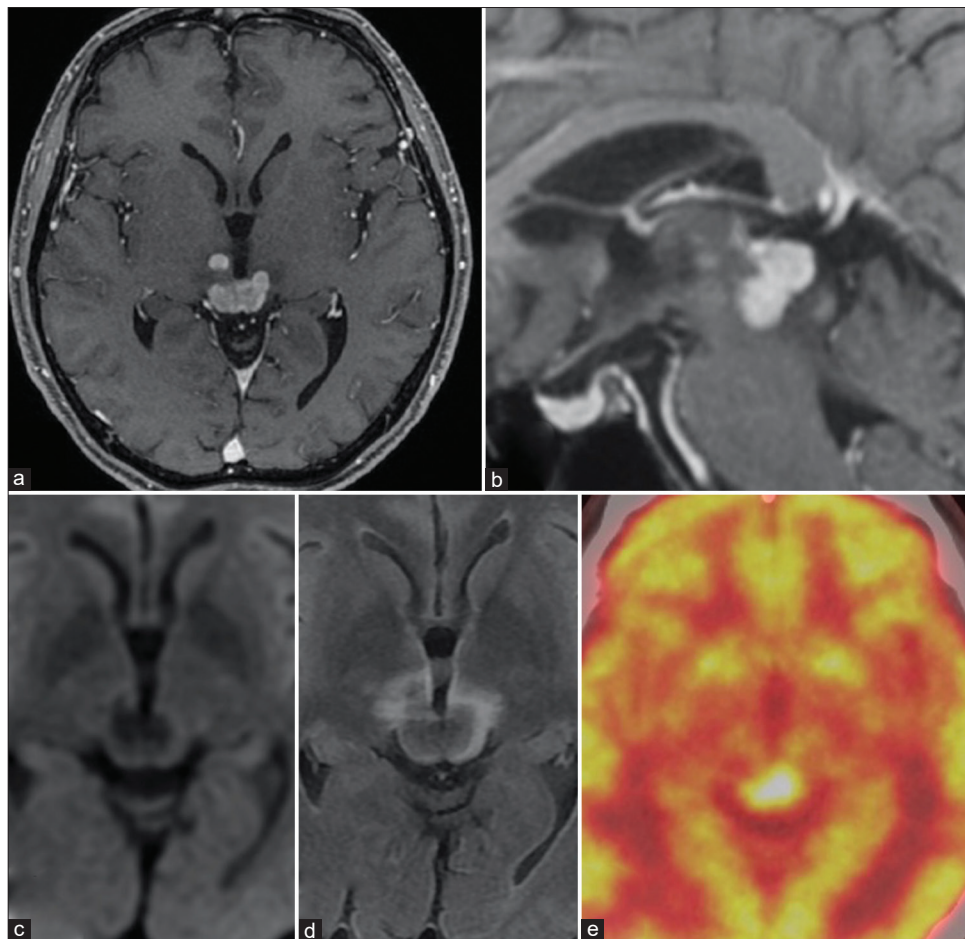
Axial (a) and sagittal (b) views of enhanced T1-weighted magnetic resonance imaging demonstrating a homogenous enhanced lesion in the dorsal midbrain and a skipped lesion in the right thalamus. The lesion exhibits low intensity on the diffusion-weighted image (c). In the fluid-attenuated inversion recovery image, the lesion is isointense and is accompanied by perifocal edema (d). Positron emission tomography reveals ^{18}F -FDG uptake in the lesion (e).
